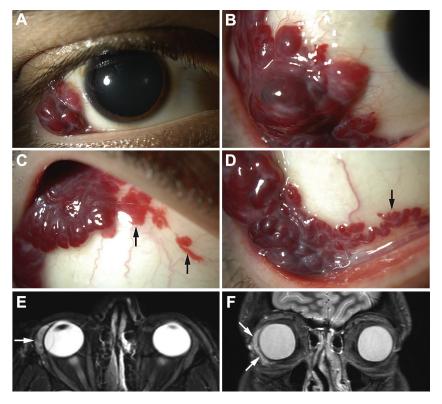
Conjunctival venous malformation. A: A reddish-blue multilobular, movable mass in the inferotemporal quadrant of the right eye of a 33-year-old man had been present since birth. It had been asymptomatic until a recent abrupt enlargement. B: Close-up view of the lesion with irregular epibulbar margin. C: The mass extended to the superolateral fornix and was associated with small flat subconjunctival hemorrhage (arrows). D: Enlarged, probably venous channels (arrow) in the inferior fornix blend with the mass. E: Axial magnetic resonance image reveals an anterior orbital component of the lesion in the vicinity of the lacrimal gland (arrow). F: Coronal MRI demonstrates that the anterior orbital component involves the tissues lateral to the globe from the lacrimal region (top arrow) to the inferior orbit (bottom arrow).
